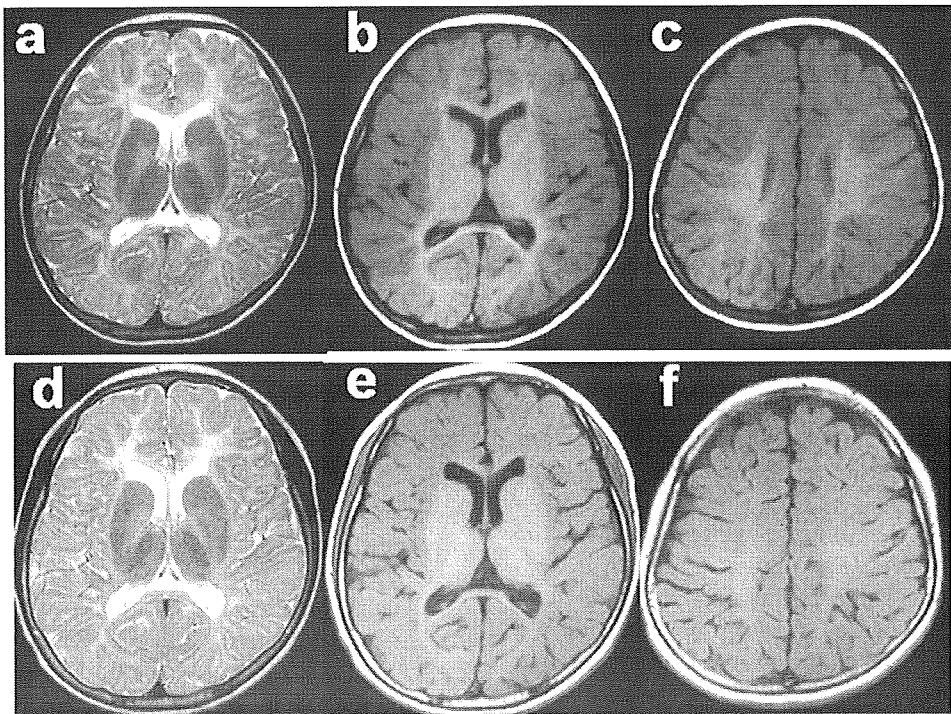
Axial MRI of patient 1. At 4 years of age (above), diffuse high-intensity areas can be seen throughout the white matter in T2-weighted image (a) and high-intensity areas are evident in the central white matter in T1-weighted images (b, c), indicating diffuse hypomyelination. At 11 years of age (below), T2-weighted image shows findings (d) identical to that seen at 4 years of age. T1-weighted images show that the area of myelinated white matter is reduced (e, f) compared with that seen at 4 years of age, indicating a progressive disorder. The volume of basal ganglia is normal.
